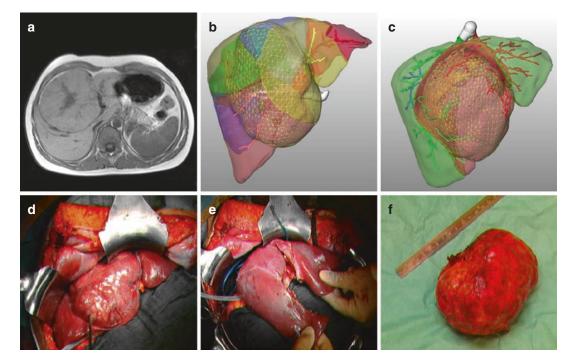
Focal nodular hyperplasia (FNH) in a 12 yearold girl. (a) MRI scan showing the centrally located tumor. (b) 3D reconstruction of liver with portal venous
